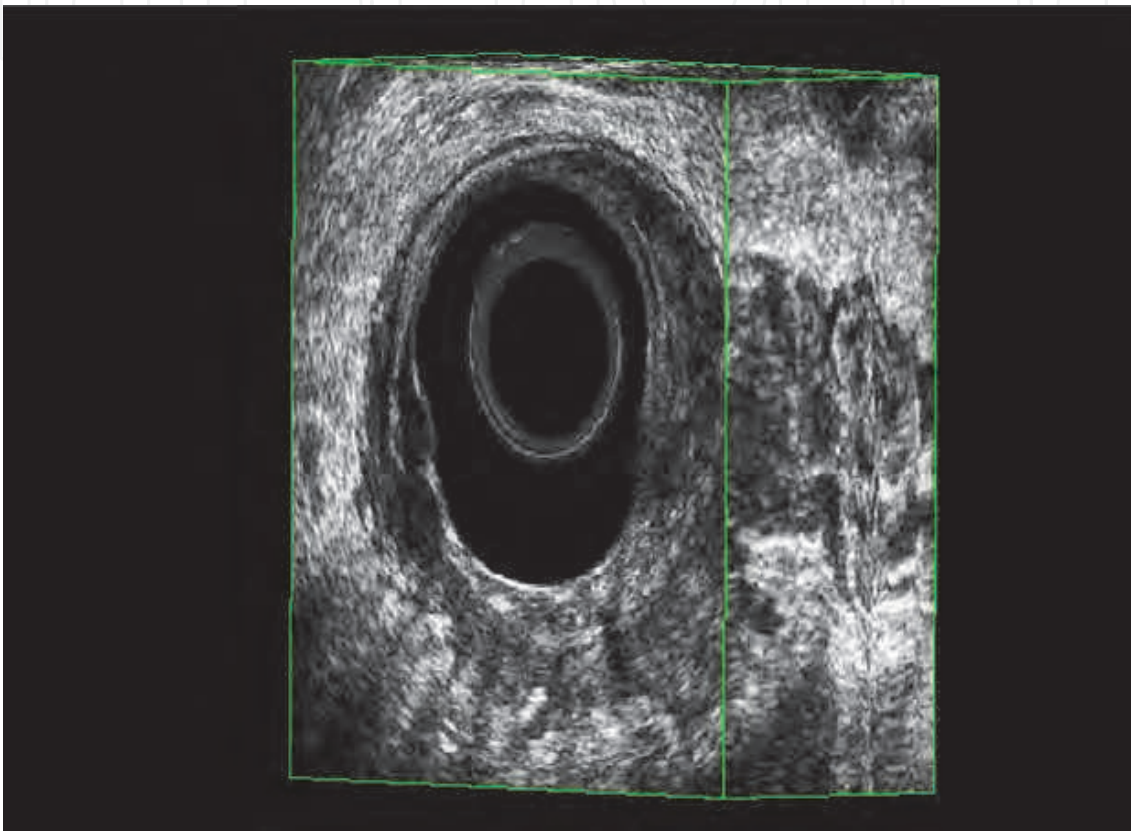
Perirectal fat invasion (uT3) is diagnosed sonographically by the presence of irregularity of the outer hyperechoic layer that corresponds to the perirectal fat interface
